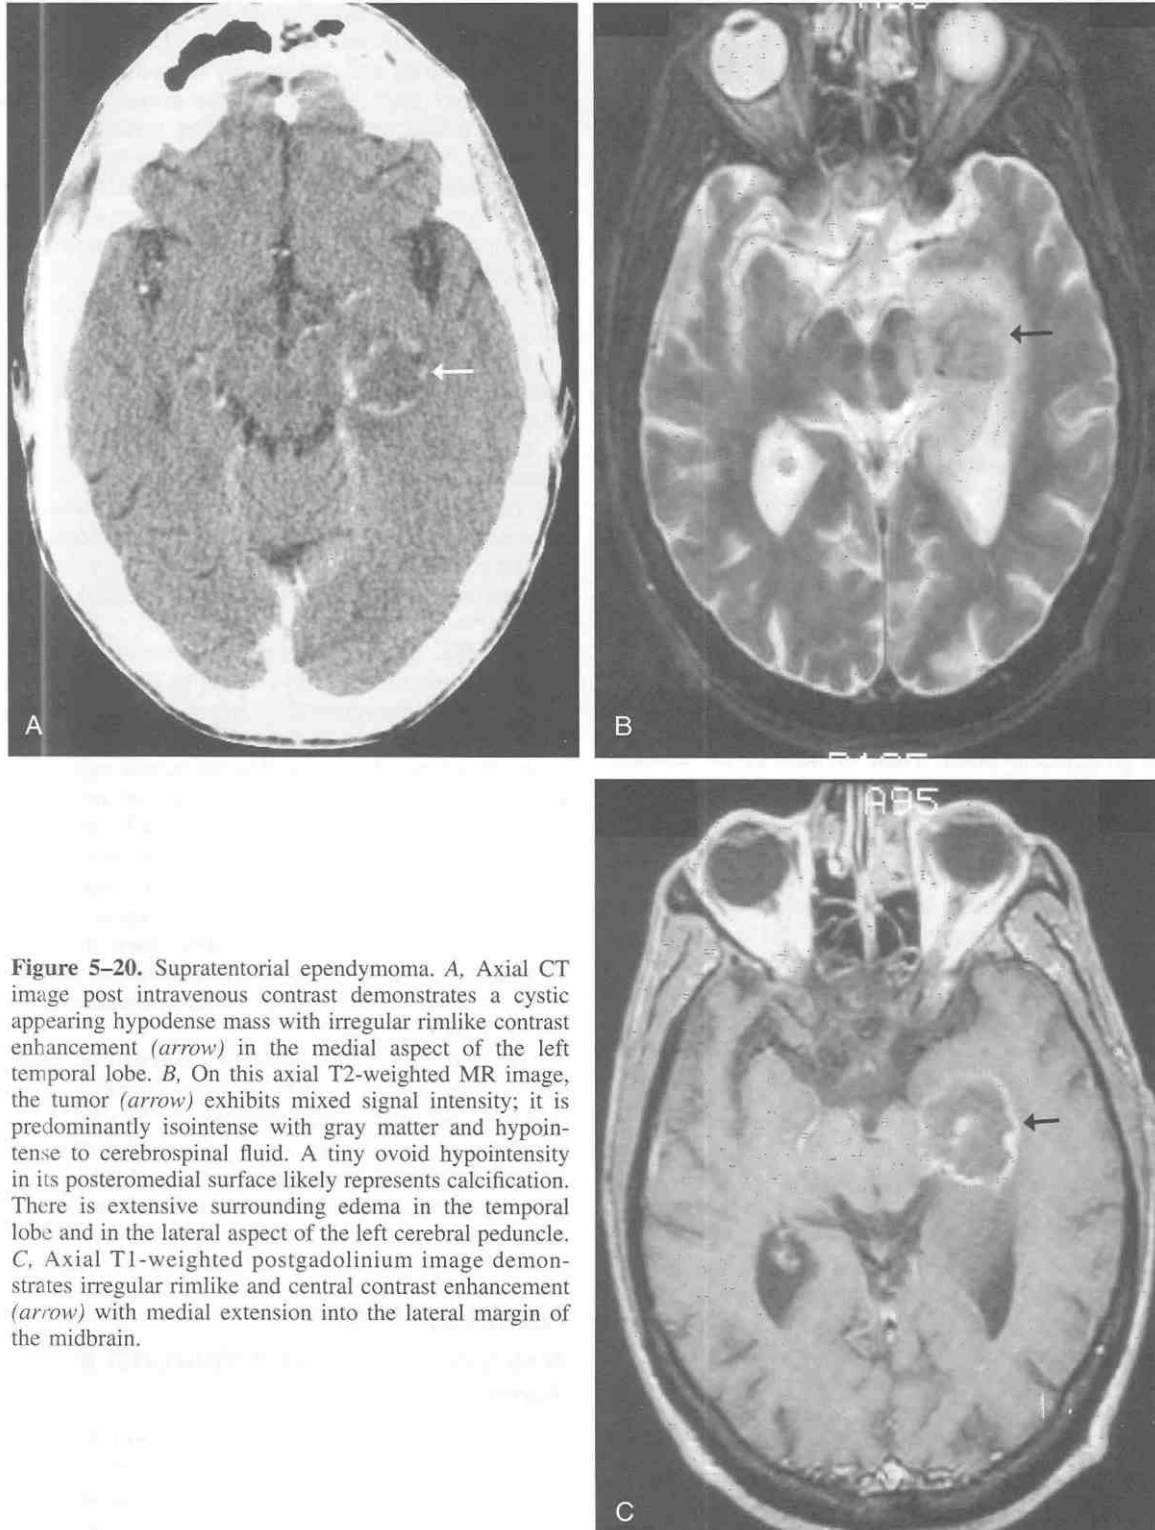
Supratentorial ependymoma. A, Axial CT image post intravenous contrast demonstrates a cystic appearing hypodense mass with irregular rimlike contrast enhancement (*arrow*) in the medial aspect of the left temporal lobe. B, On this axial T2-weighted MR image, the tumor (*arrow*) exhibits mixed signal intensity; it is predominantly isointense with gray matter and hypointense to cerebrospinal fluid. A tiny ovoid hypointensity in its posteromedial surface likely represents calcification. There is extensive surrounding edema in the temporal lobe and in the lateral aspect of the left cerebral peduncle. C, Axial T1-weighted postgadolinium image demonstrates irregular rimlike and central contrast enhancement (*arrow*) with medial extension into the lateral margin of the midbrain.
